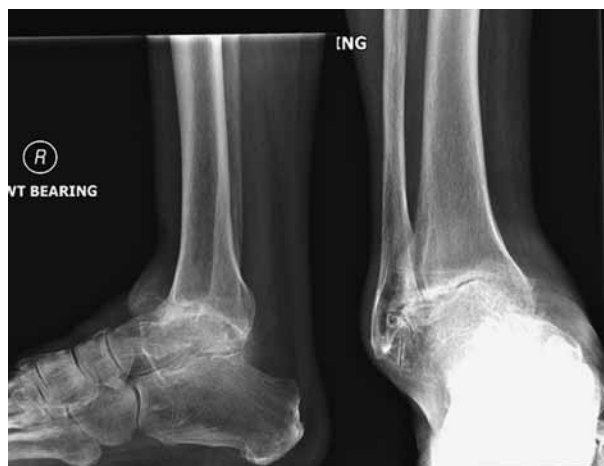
Pre-operative radiographs of a patient showing varus deformity of hind foot secondary to severe osteoarthritis.
